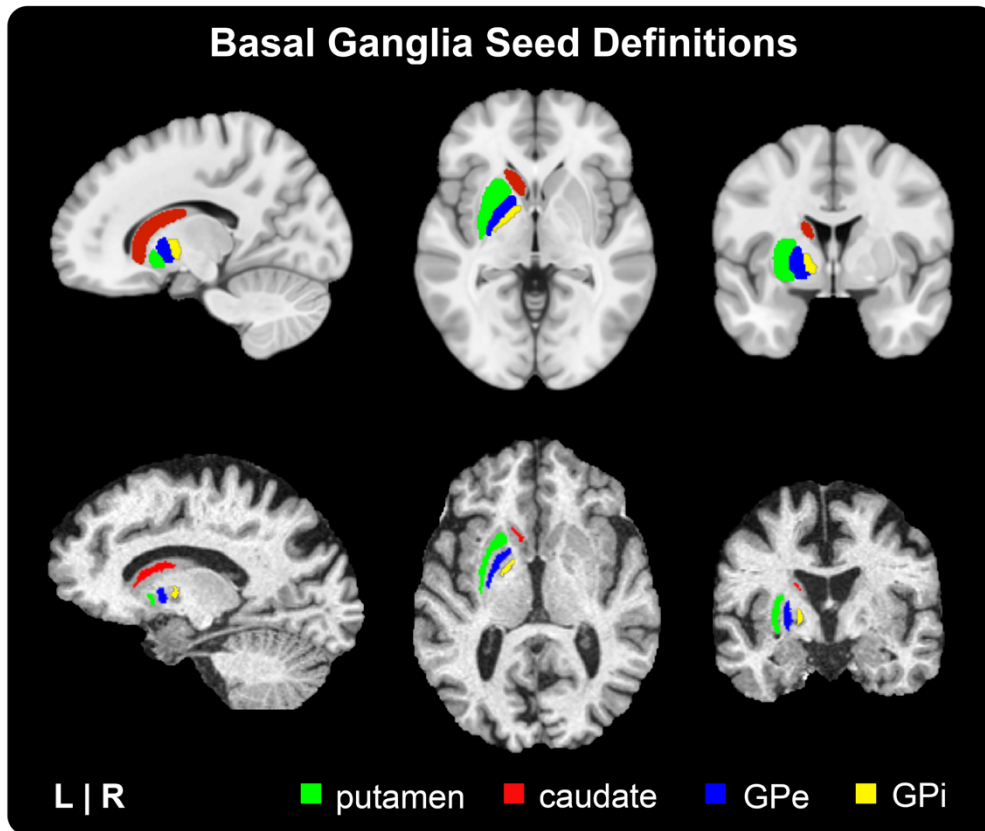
Basal ganglia seed definitions. Masks for the putamen, caudate, GPe, and GPi seeds were derived from the Basal Ganglia Human Area Template (BGHAT). Top row: BGHAT template regions overlaid onto the MNI template brain. Bottom row: BGHAT regions warped, eroded, and overlaid onto an individual subject's T1-weighted structural MRI. Abbreviations: external globus pallidus (GPe), internal globus pallidus (GPi).
